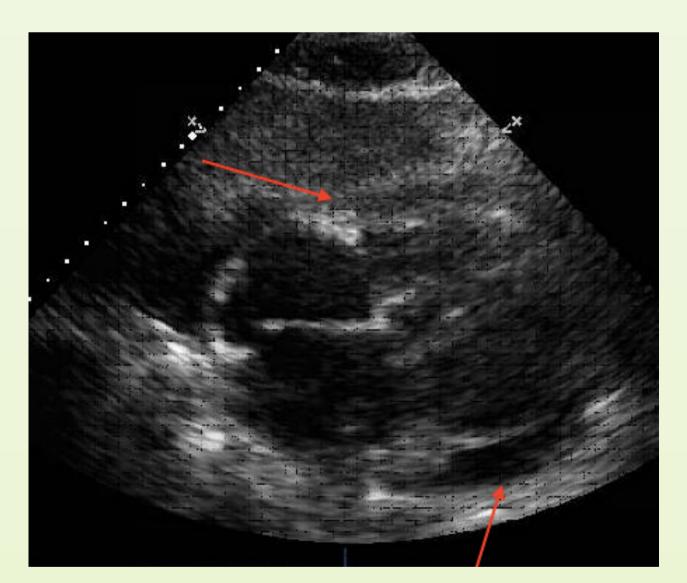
Pericardial effusion seen on echocardiogram
